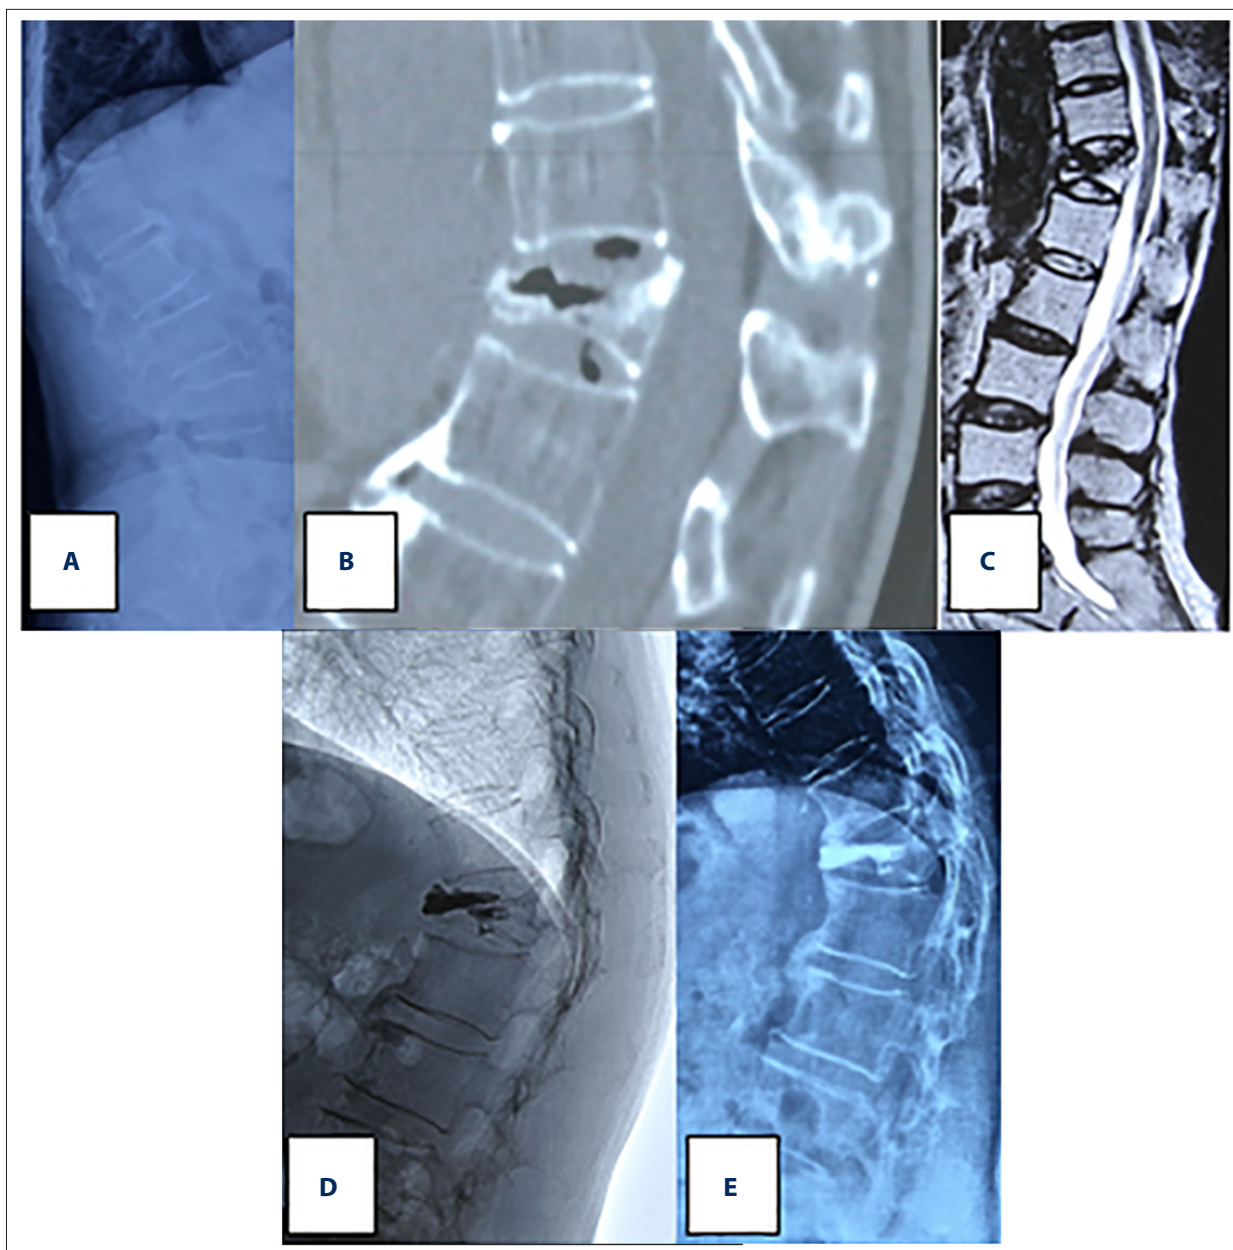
Female patient, aged 63 years, with back pain for 3 months, who underwent percutaneous kyphoplasty (PKP). (A–C) Preoperative lateral x-ray and CT scan showed L1 vertebral fracture with vacuum-like changes, MRI showed low signal of the necrotic area on T2-weighted images. (D, E) Postoperative x-ray showed that the cavity of intravertebral cleft was filled with bone cement, and the final follow-up review revealed fine cement position and satisfactory radiographic results.
